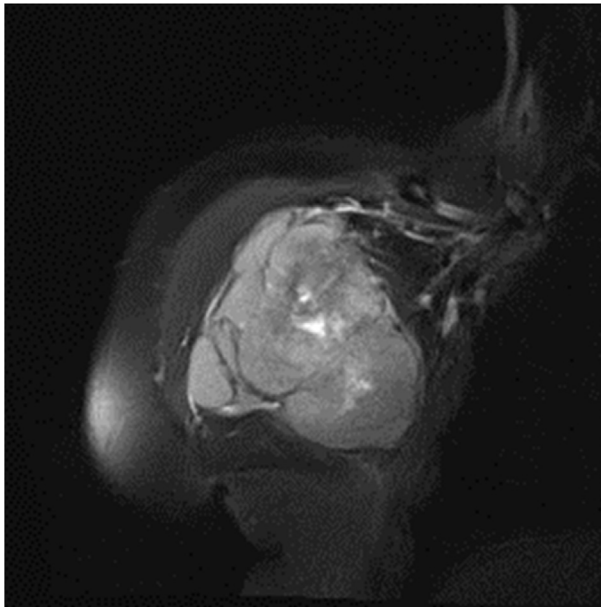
MRI scan showing intramuscular lesion involving right pectoralis major and minor muscles and encasing the axillary neurovascular bundle.
